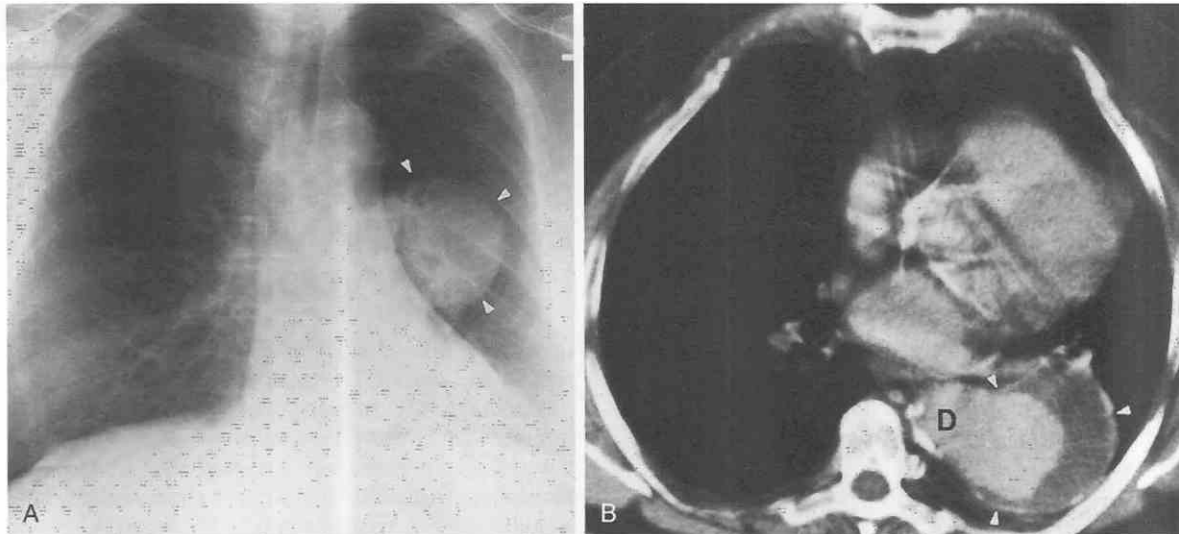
Saccular aneurysm of descending aorta. *A*, Posteroanterior chest radiograph shows homogeneous soft tissue mass (arrowheads) in the left hemithorax. Acute margins at interface with mediastinum suggest intrapulmonary mass. *B*, Contrast-enhanced CT shows saccular aneurysm (arrowheads) of descending aorta (D) with peripheral thrombus.
